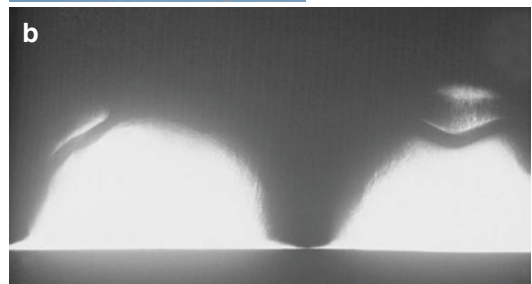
(a) Congenital dislocation of the right patella. (b) Axial X-ray of both patellofemoral joints. The right patella is laterally dislocated. An absent femoral groove on the right side is noticeable
